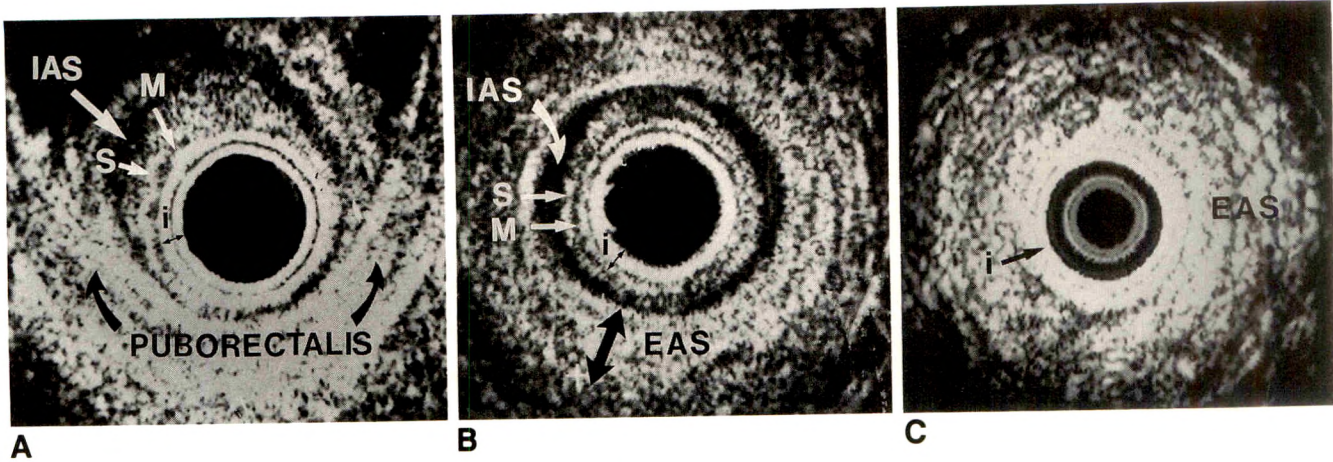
Endoluminal anal sonograms. Transverse images (seen from below, up is anterior).
